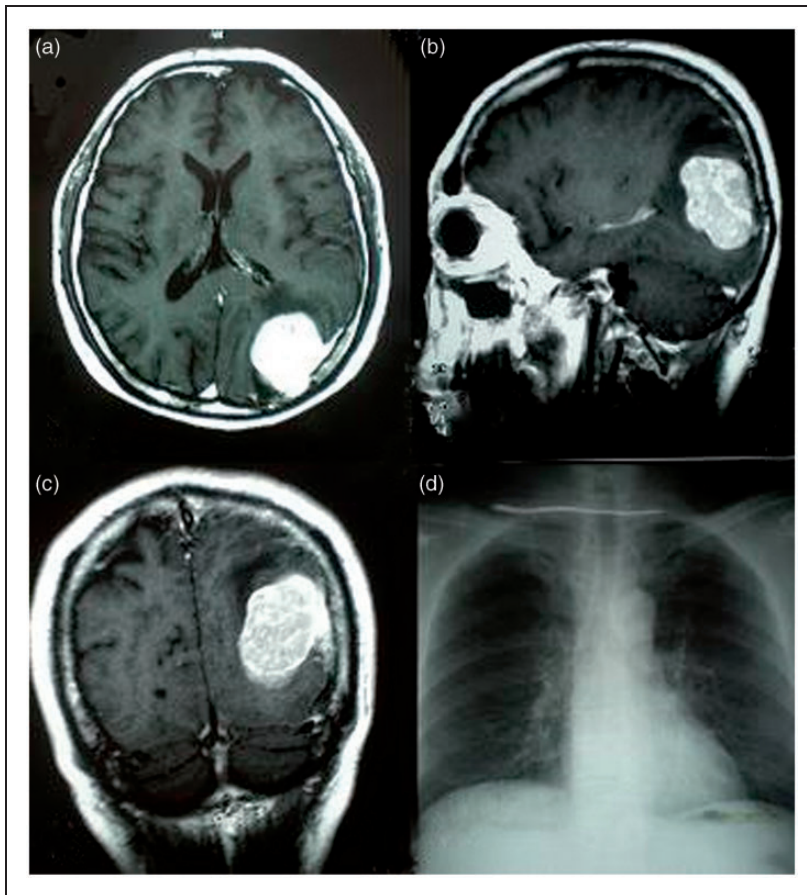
Preoperative magnetic resonance imaging in a male patient with intracranial meningioma: T1-weighted with contrast medium showing a homogeneously enhancing tumour in the left occiput: (a) axial; (b) sagittal; (c) coronal views. (d) Normal chest X-radiography taken before the first craniotomy in 2009.
